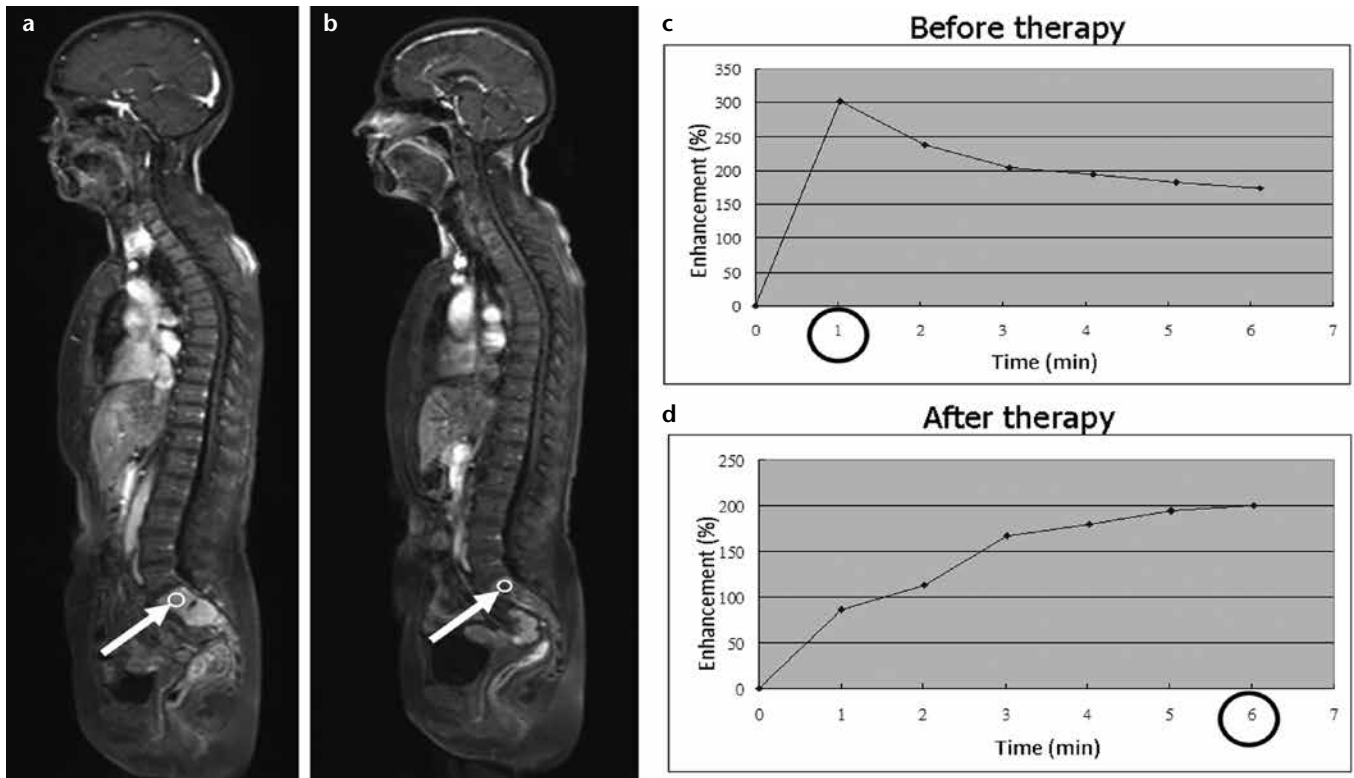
a–d. A 64-year-old female before and after induction chemotherapy for multiple myeloma. The sagittal fat-suppressed dynamic contrast-enhanced T1-weighted image of the spine (a) shows a lesion with early enhancement after contrast administration (arrow). The sagittal fat-suppressed dynamic contrast-enhanced T1-weighted image after therapy (b) shows late enhancement of the same location, indicating post-therapeutic edema (arrow). The maximum focal lesion enhancement was seen at 1 min before therapy (c) and at 6 min after therapy (d).
